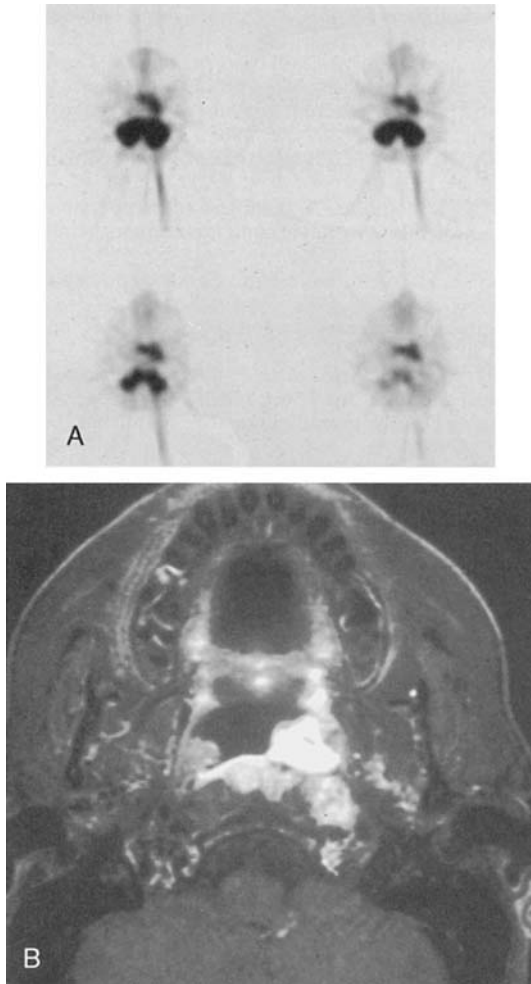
A*, Axial fluorodeoxyglucose (FDG) PET images of the nasopharynx and posterior fossa reveal abnormal FDG uptake in the left nasopharynx (squamous cell carcinoma). Note normal brain uptake in the cerebellum. *B*, Postgadolinium T1-weighted MR images show corresponding enhanced left nasopharyngeal mass and medial and lateral retropharyngeal nodes.
